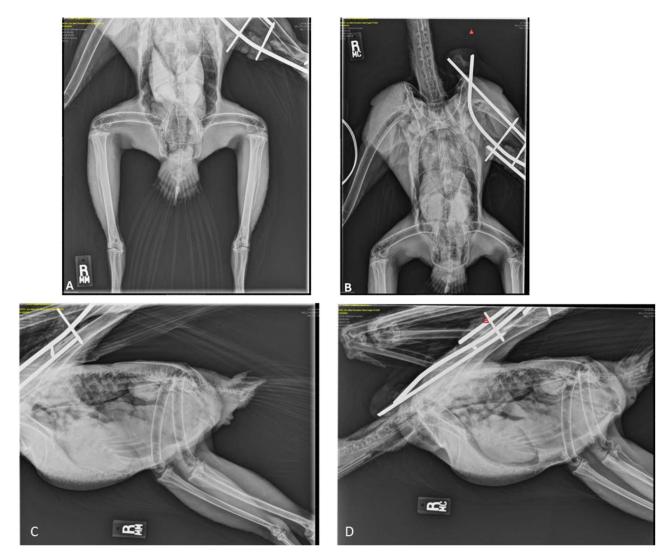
Case 1, (A) dorsoventral and (C) lateral radiographs of an adult bald eagle (*Haliaeetus leucocephalus*) demonstrating radiographic evidence of cardiomegaly (heart 66% of thoracic width; reference interval 44%–52%); (B) dorsoventral and (D) lateral radiographs demonstrating improved cardiomegaly approximately 6 days after initial diagnosis.
